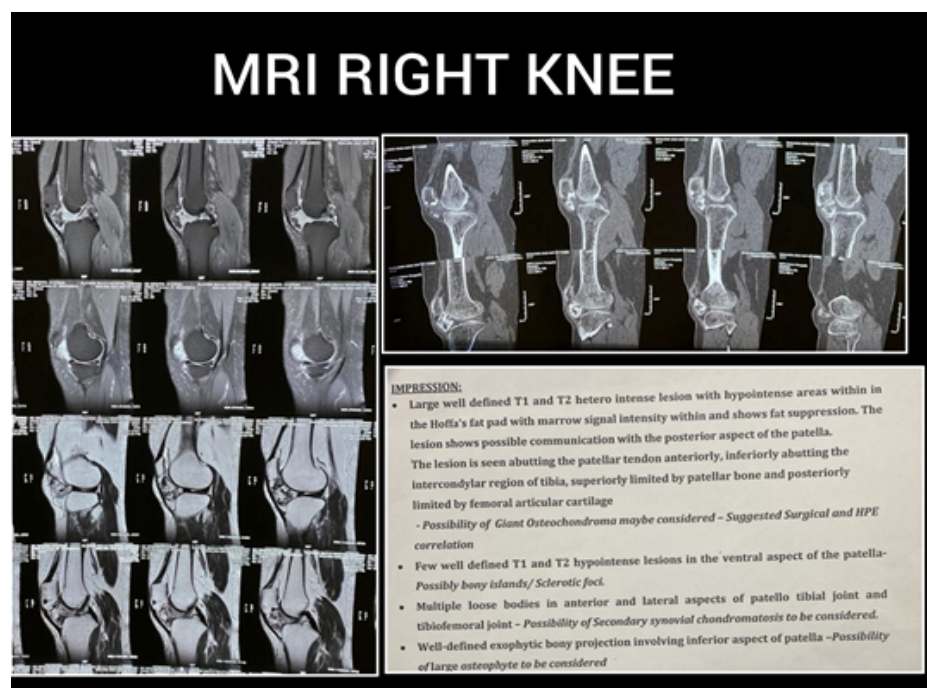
Magnetic resonance imaging right knee.
